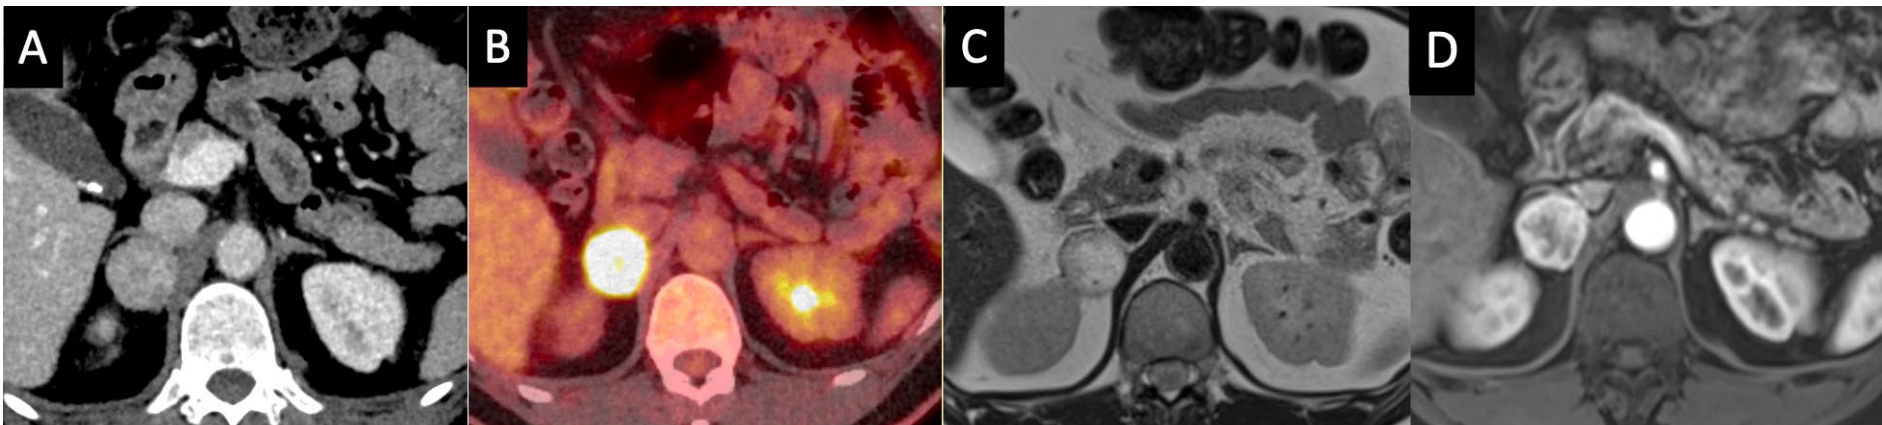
Contrast-enhanced CT (A) and PET 18FDG fusion demonstrating intense tracer uptake in the heterogenous right adrenal mass. On MRI, the lesion has a high signal on T2W (C) and cystic unenhanced portions on T1W post Gadolinium (D) sequences.
